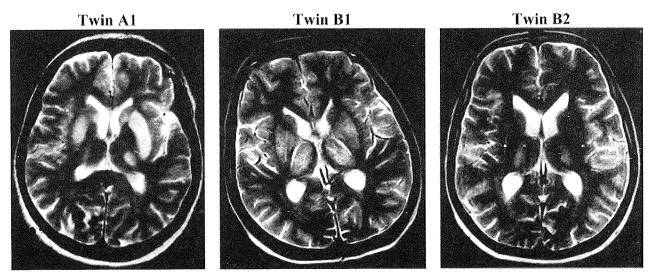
The brain MRI: hyperintensive areas on T2-weighted images of the basal ganglia and thalami are visible in twin A1, and twins B1 and B2 (changes are more advanced in twin B1 than in B2).
